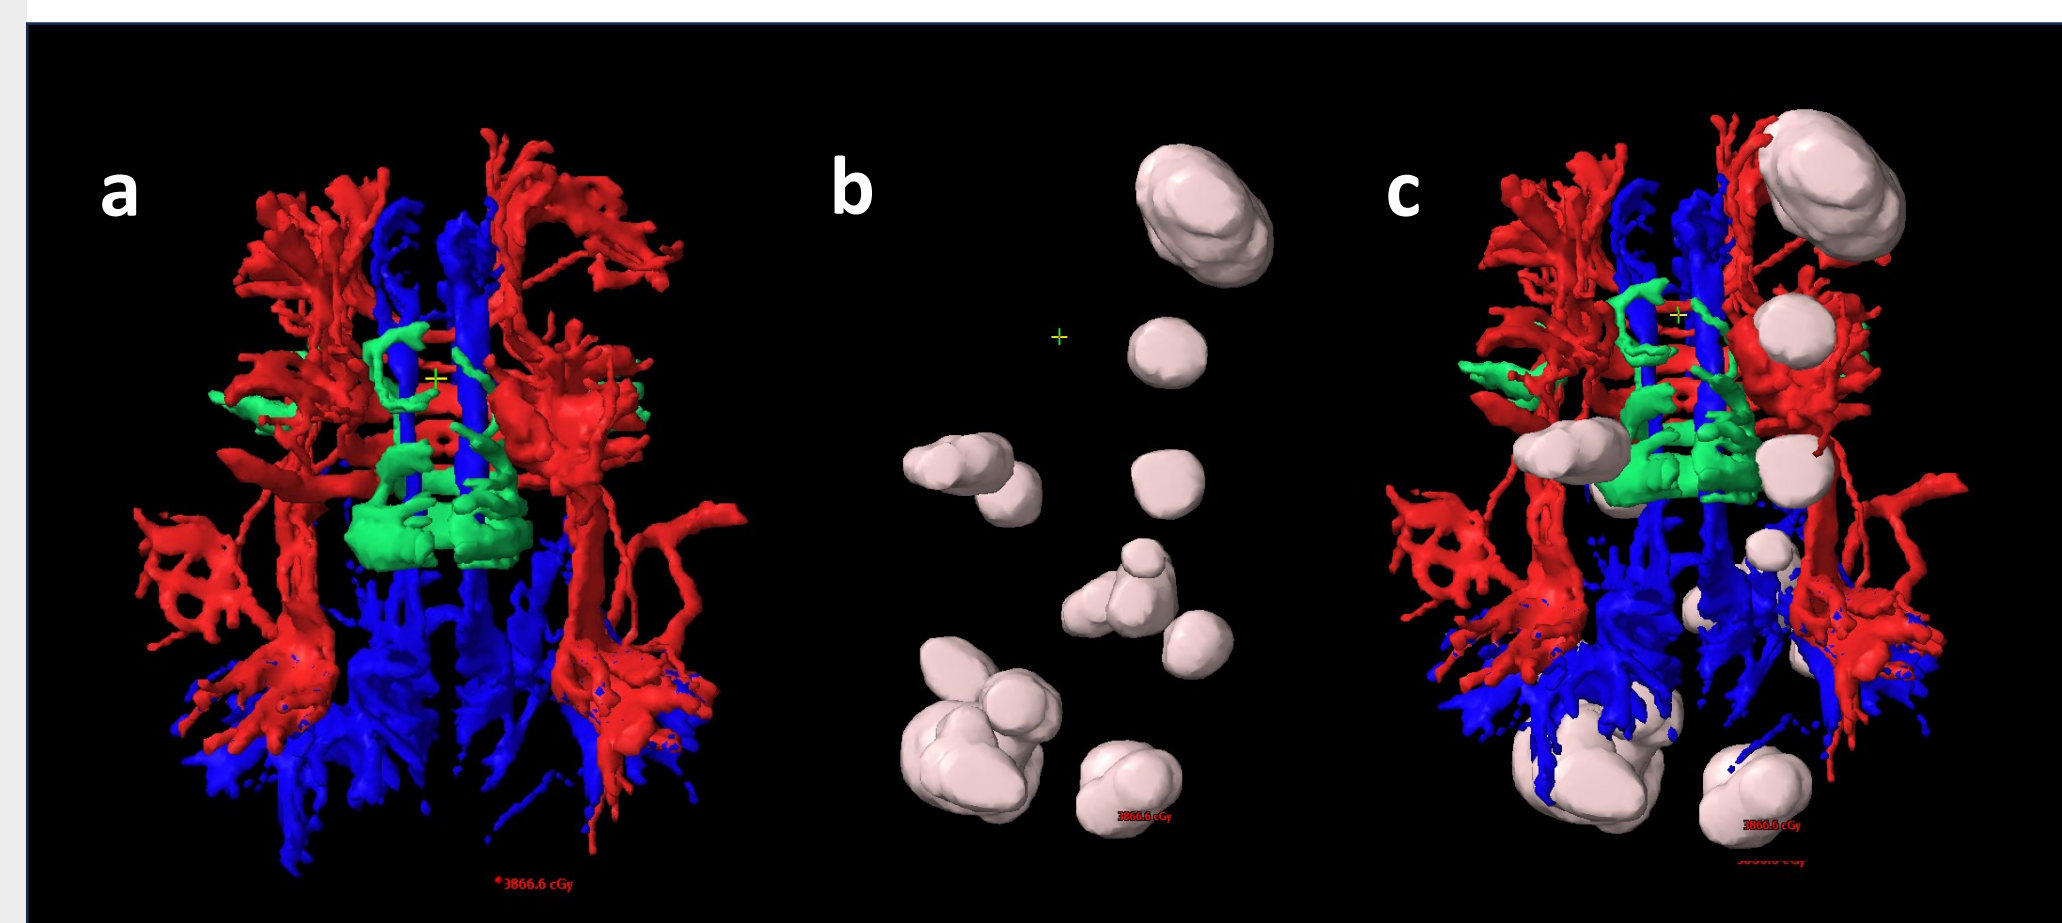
Case 5. (a) Patient-specific connectome showing white-matter tracts associated with CEN (red), DMN (blue), and SN (green). (b) Thirteen lesions identified on post-contrast T1-weighted MRI. (c) Co-registration of the triple-network tracts with the lesions.
